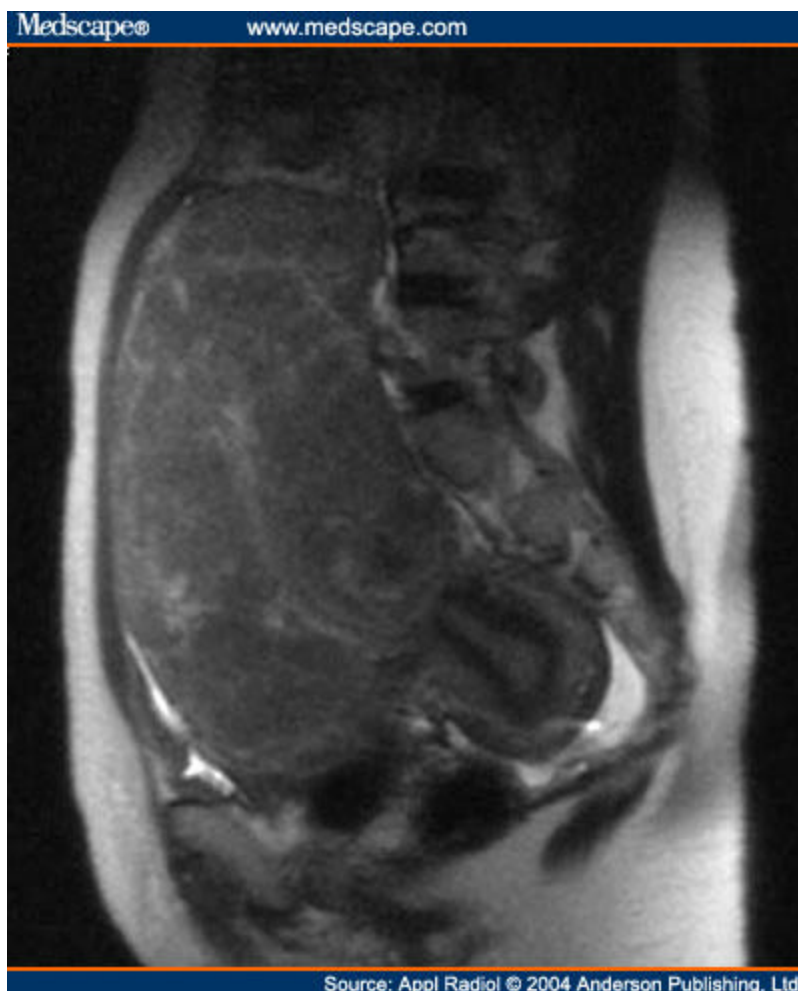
Sagittal T2-weighted MRI of a very large fibroid uterus. This patient was not considered a candidate for uterine artery embolization because her uterus was thought to be too big.
